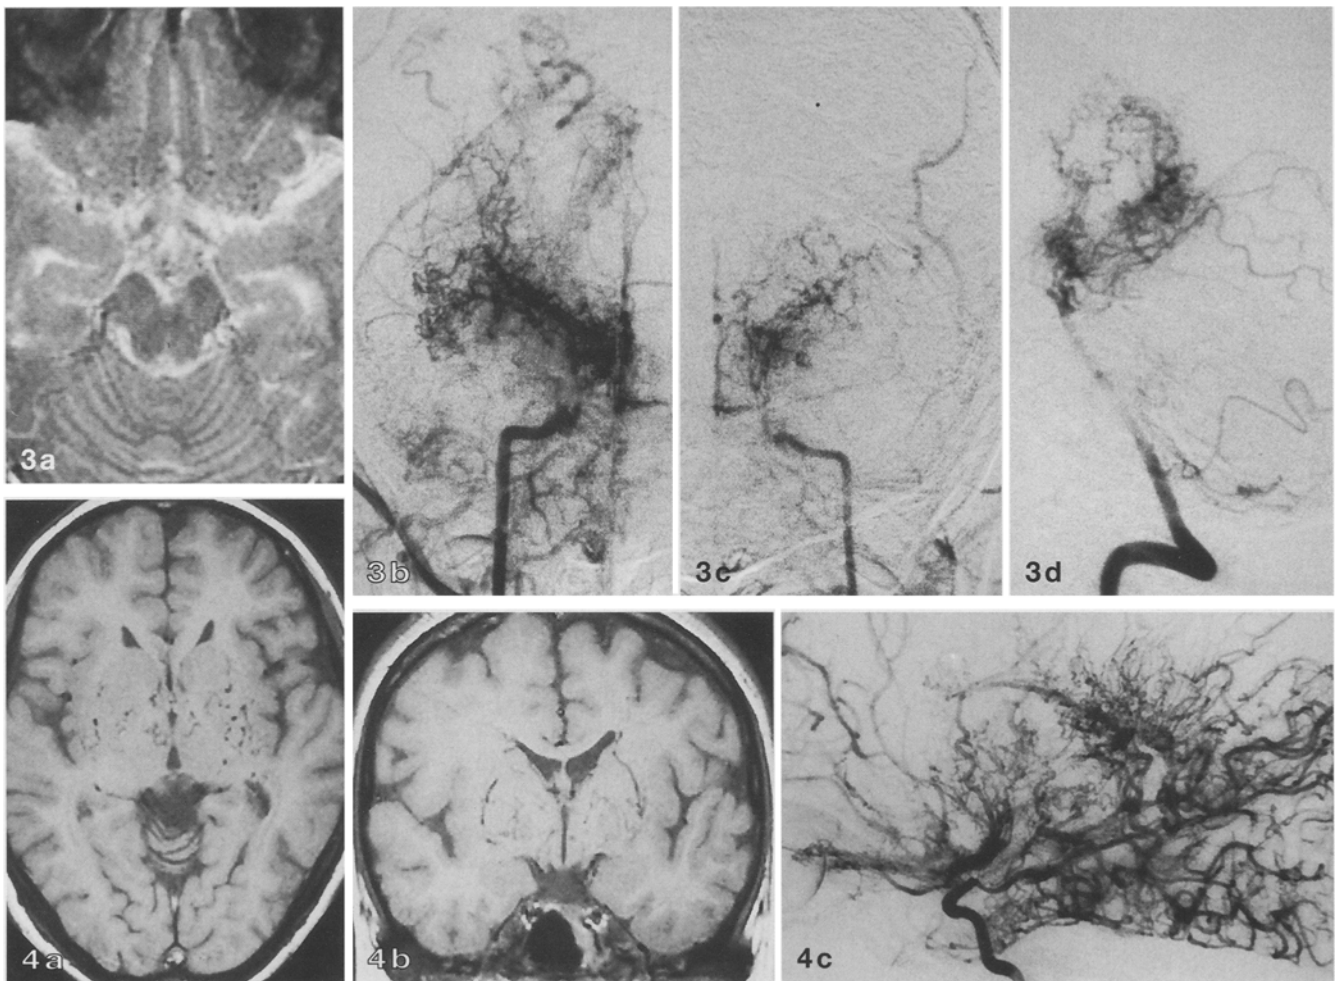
A 13-year-old girl. a Axial T2-weighted image shows that the supraclinoid ICA and the proximal ACA, MCA and PCA are occluded bilaterally. b Right internal carotid arteriogram, frontal projection, shows that the ICA is occluded in its distal supraclinoid portion and the ACA and MCA in their proximal portions. Marked MMV are seen. c Left internal carotid arteriogram, frontal projection, shows that the supraclinoid ICA and the proximal ACA and MCA are markedly stenotic. Moderate MMV are seen. d Left vertebral arteriogram, lateral projection, shows that both PCA are occluded proximally. Marked MMV are seen
